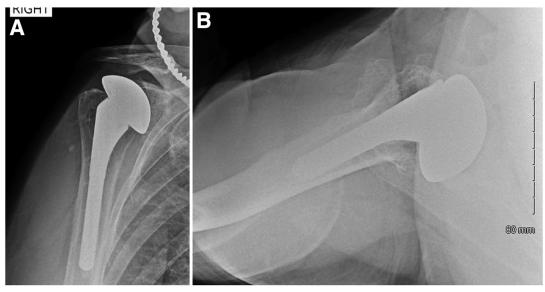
Postoperative true anteroposterior (A) and axillary-lateral (B) radiographs at 8 weeks demonstrating bone graft remodeling and maintenance of glenohumeral register.
